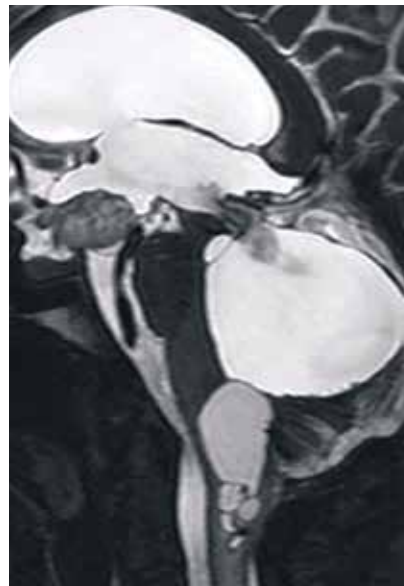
Postoperative sagittal T2-weighted magnetic resonance imaging showing the flow from fourth ventricle, the cysts associated with obex and bulb-medullary junction hemangioblastomas without hemorrhagic complications
